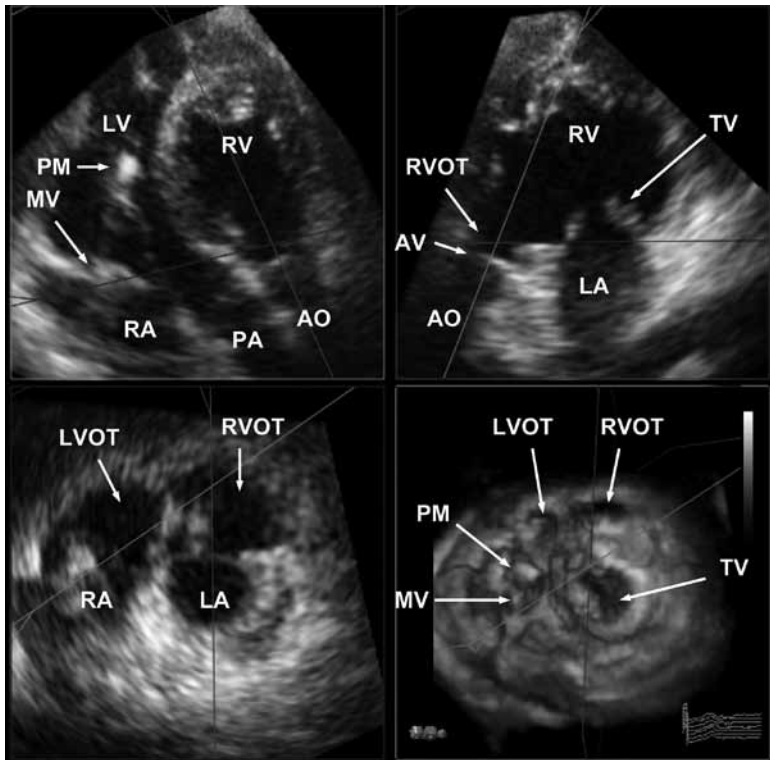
Transthoracic RT3DE dataset with multiplane representation in a 42-year-old woman with ccTGA with the aortic valve (connected to RVOT) left and anterior (bottom right). Individual orientation of the three image planes (red, green, blue) allows for the most comprehensive crosssectional representation of the abnormal anatomic relationships. LV left ventricle, RV right ventricle, RA right atrium, LA left atrium, MV mitral valve, TV tricuspid valve, LVOT left ventricular outflow tract, RVOT right ventricular outflow tract, AO aorta, PA pulmonary artery, PM pacemaker lead.
